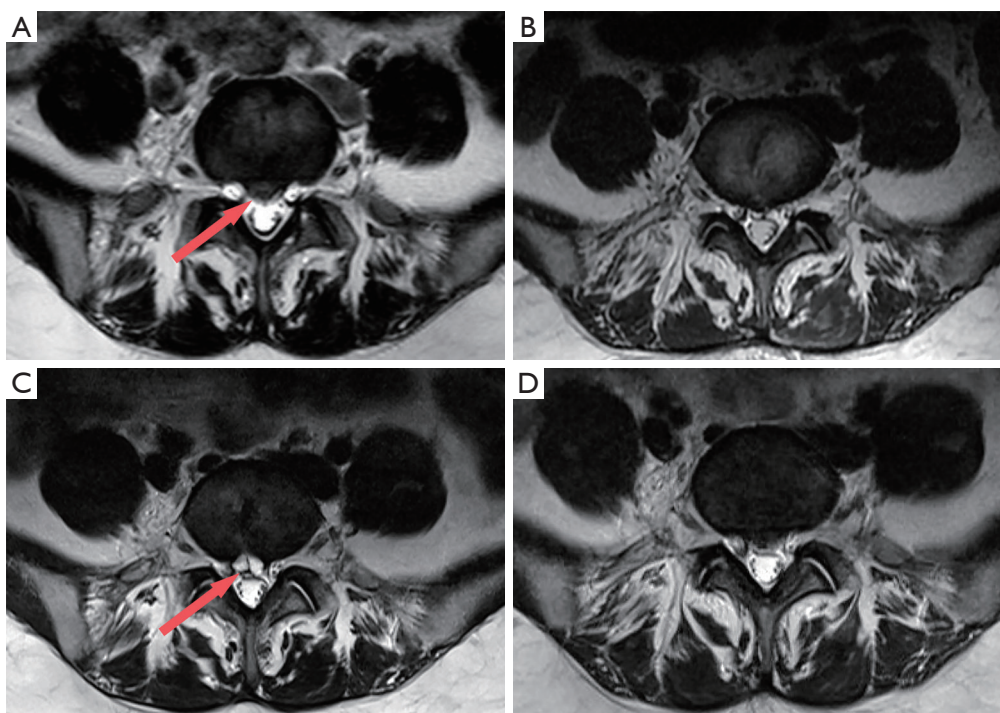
MRI images in a 25-year-old woman who presented with a 1-year history of chronic low back pain, 8 months of radiating pain, and 4 months of numbness in both lower limbs. (A) Preoperative lumbar MRI showed L5/S1 disc herniation (red arrow). (B) MRI on the first postoperative day revealed no disc herniation. (C) A routine follow-up MRI 4 months after surgery suggested postoperative discal pseudocyst (red arrow). (D) MRI displayed the cyst disappeared at 7 months after the surgery. MRI, magnetic resonance imaging.
